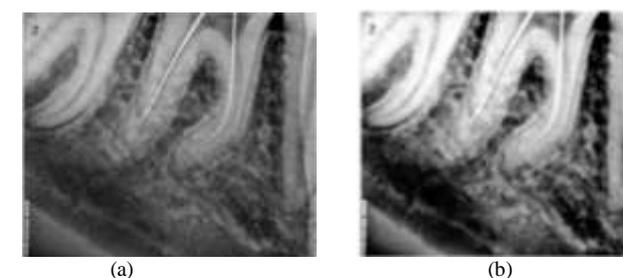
(a) Dental single –rooted CBCT input image (b) Output image after Histogram (c) Output image after CLAHE (d) Output after MSR (e) Output after Fuzzy enhancement.
